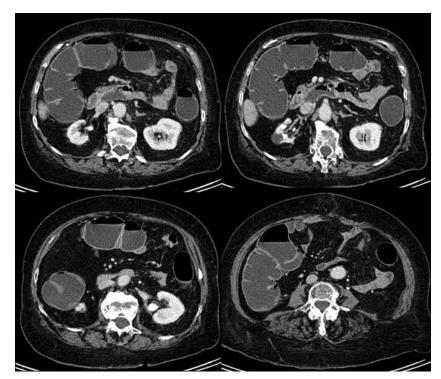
Axial CT images demonstrate good distension of different colon segments with tap water instead of room air/CO₂.
